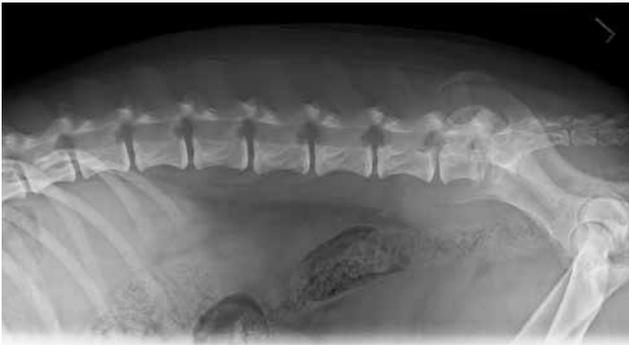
Laterolateral radiograph of the lumbosacral region in a neutral position. There is narrowing of the intervertebral disc space at the lumbosacral joint. The adjacent endplates of L7 and S1 are irregular.
